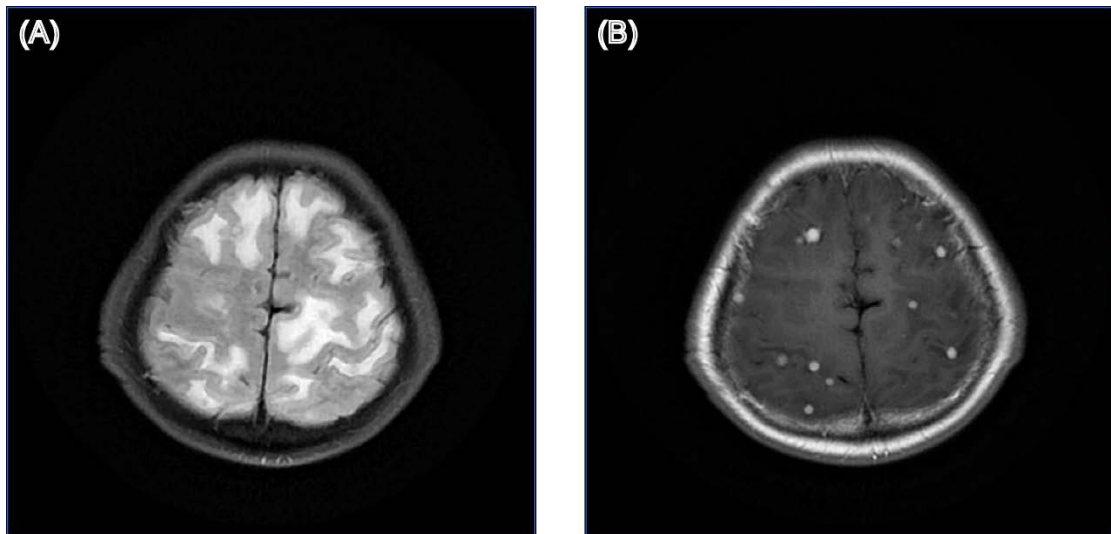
Structural brain MRI images of patient 24. (A) T2-weighted fluid-attenuated inversion recovery (T2-FLAIR) image; (B) Gadolinium-enhanced T1-weighted (Gd-T1w) image.
